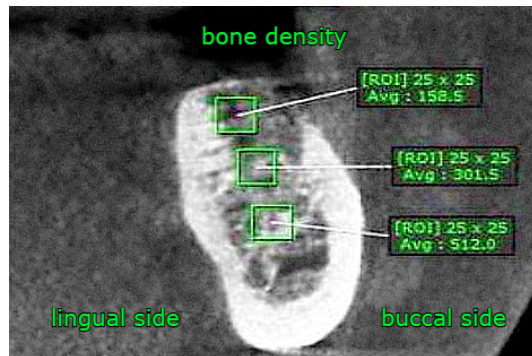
Coronal view Cone Beam CT showing bone density measurement
